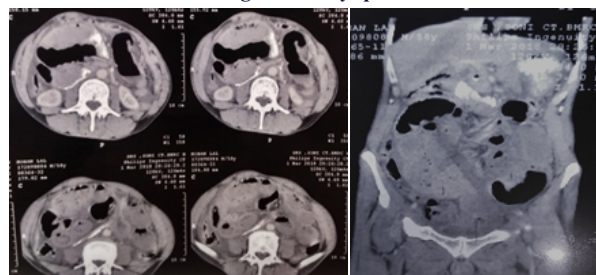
CT showing the right upper cluster of bowel inside the hernia sac with a deficit of contrast capitation.
